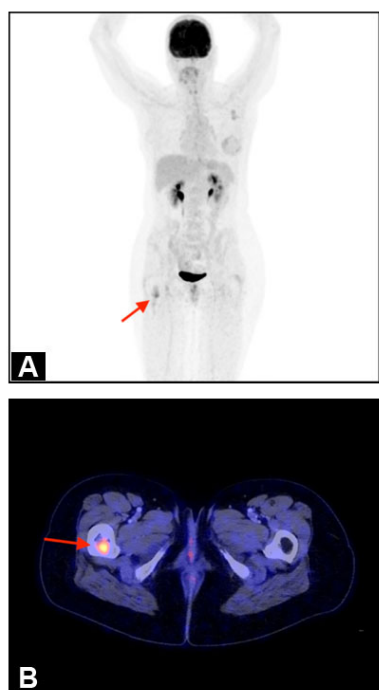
Maximum intensity projection (MIP) image (A) and axial fused FDG PET CT image (B) from case 2—a 55-year-old female's post-operative staging FDG-PET/CT identifying a moderately FDG avid (SUV_{max} 5.1) right proximal lytic femoral lesion with sclerotic margins extending into the right femoral neck (arrows). The sclerotic margins appeared relatively well-circumscribed within a part of the lesion. This lesion was later confirmed to be fibrous dysplasia on biopsy.
